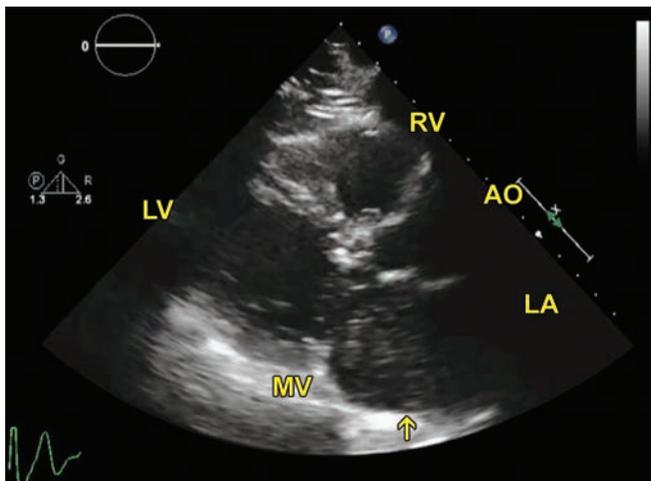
Transthoracic parasternal long axis view. Arrow points to the large mass filling most of LA.
